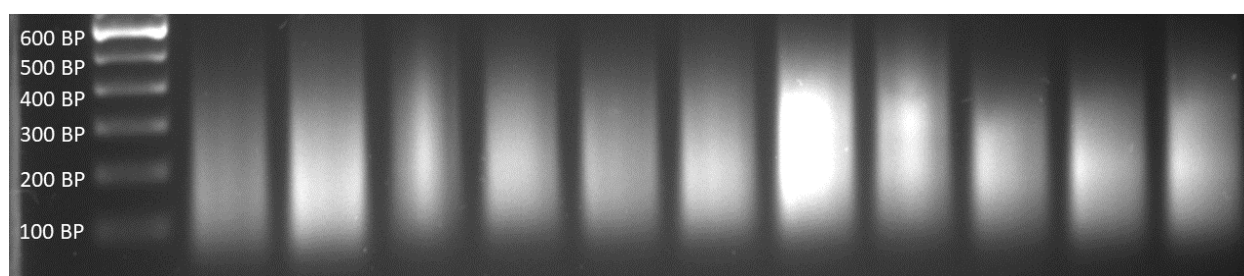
UV picture of DNA sonicated as outlined using the Covaris E220 Focused Ultrasonicator for DNA immunoprecipitations. DNA is fragmented to a 100-600BP range with a peak around 200BPs
